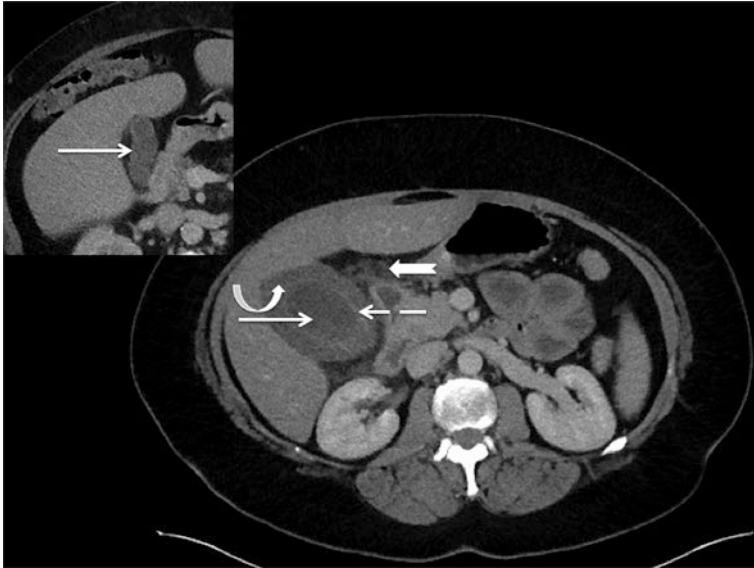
A 76-year-old woman with a history of dementia presents with generalized abdominal pain, pyrexia and raised inflammatory markers. Axial contrast-enhanced CT abdomen demonstrates a distended gallbladder (solid arrow), which is of low attenuation due to fluid but which demonstrates a high attenuation/enhancing wall (dashed arrow). There is large volume low attenuation pericholecystic fluid (curved arrow) and high attenuation inflammatory fat stranding (notched arrow). Findings are in keeping with acute cholecystitis. (Inset: See normal gallbladder (solid arrow) for comparison). The patient underwent emergency percutaneous (US-guided) cholecystostomy due to severe sepsis
